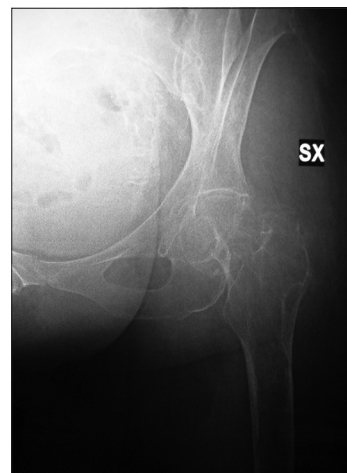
6 months radiographic follow-up showed complete healing of the fracture
